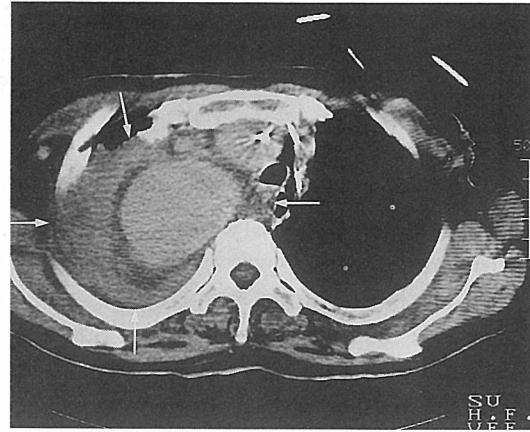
D, Contrast-enhanced CT scan obtained with mediastinal windows shows the aneurysm surrounded by hematoma, i.e. pseudoaneurysm (arrow).
